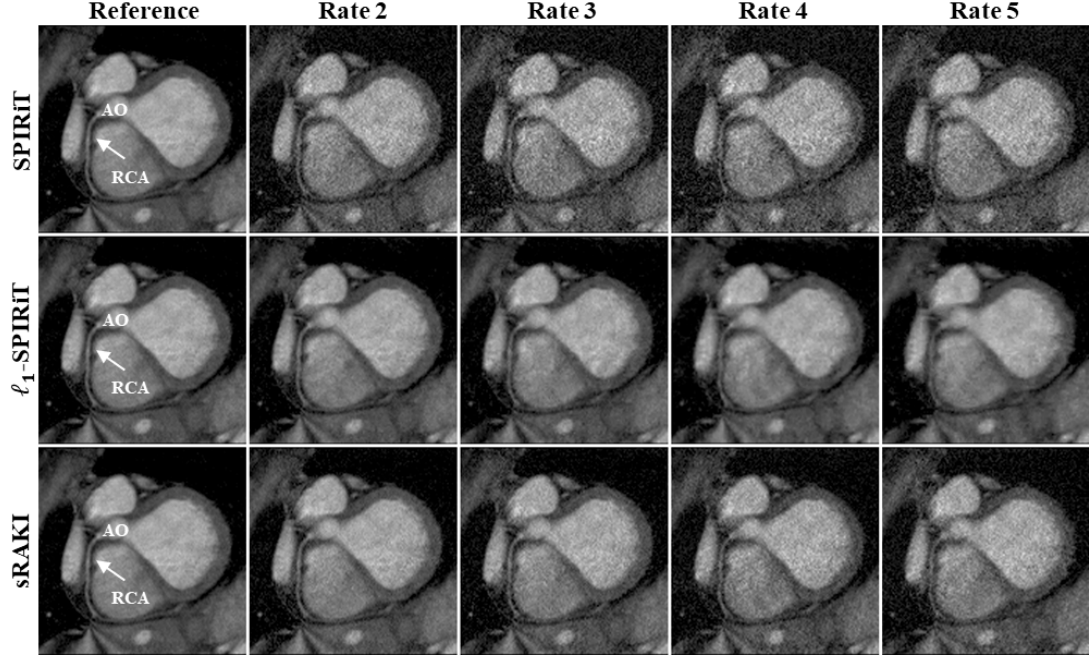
Reformatted right coronary artery (RCA) images from another 3D targeted coronary MRI dataset. This data was also retrospectively under-sampled at rates 2, 3, 4, and 5, and fully-sampled images are shown in the first column as reference. The difference between SPIRiT and sRAKI is visually evident at all acceleration rates for this subject with more apparent noise amplification. Furthermore, compared to l_1 -SPIRiT, sRAKI is more robust to blurring artifacts with increasing acceleration rates. (RCA: right coronary artery; AO: Aortic Root)
